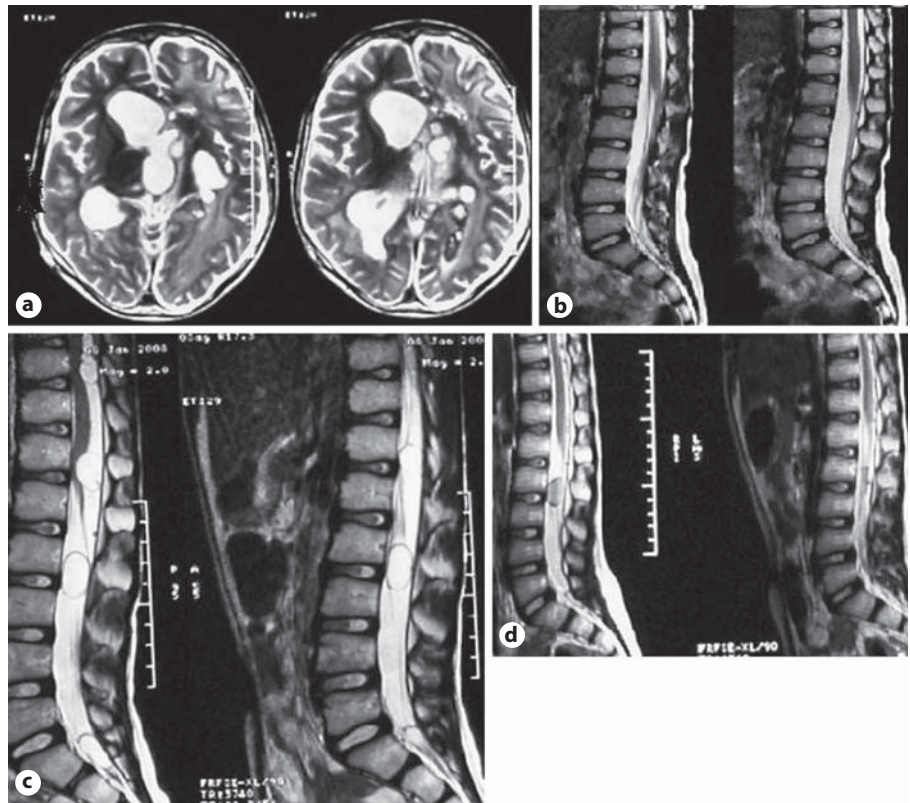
a Multiple cerebral hydatid cysts. b The spinal MRI revealed no pathologic lesions in the spinal column. c Multiple spinal seedlings of hydatid cysts 6 months after the patient's admittance to our clinic. d The last condition after 6 months of albendazole treatment.
